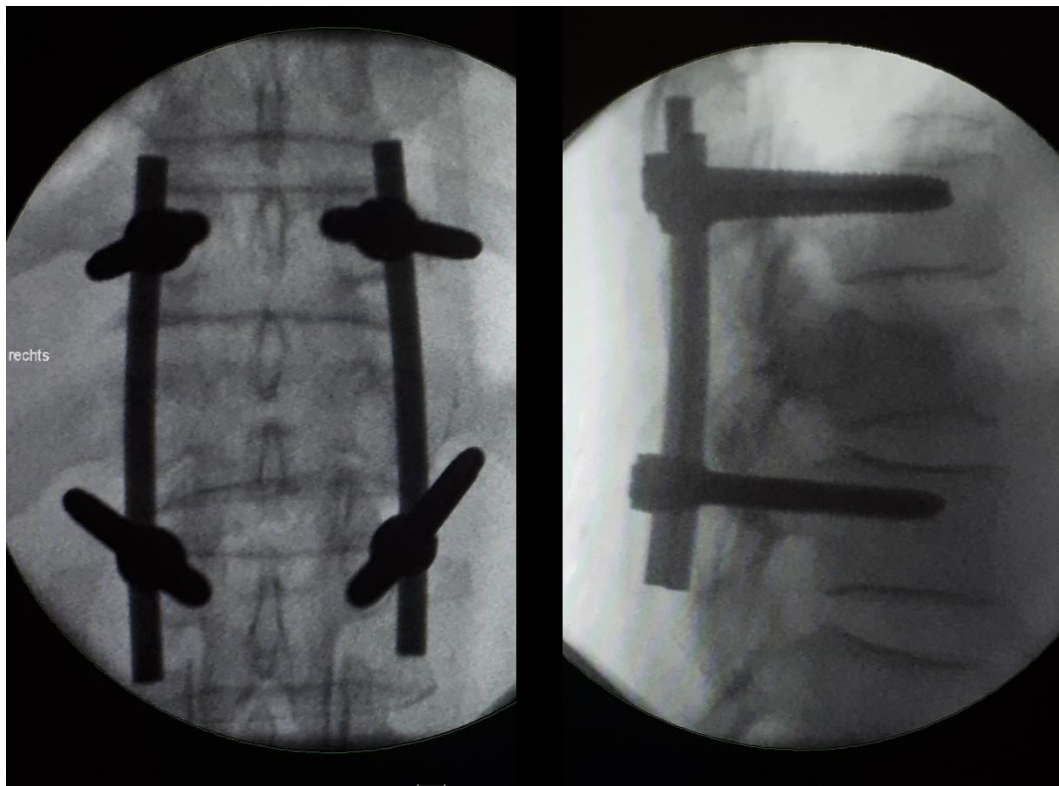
intraoperative x-ray image of a dorsal instrumentation by a Th12 body fracture
